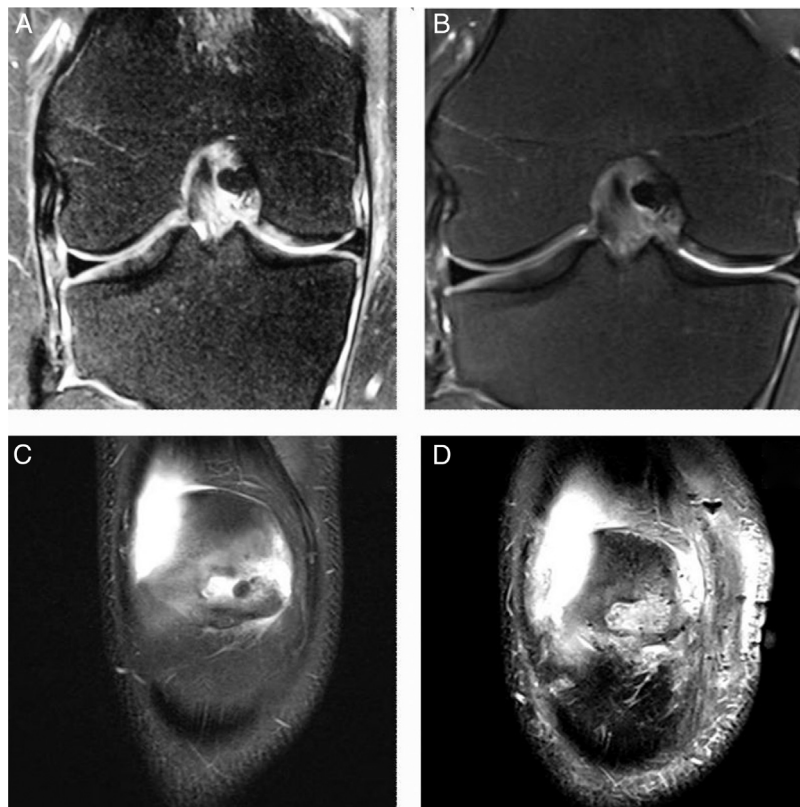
Magnetic resonance imaging of two patients who underwent surgical treatment, preoperatively and 1 year postoperatively. (A) A T2-weighted coronal section showing a chondral lesion on the inner side of the medial femoral condyle. (B) A postoperative image showing the resurfacing of the previous cartilaginous lesion. (C) A coronal image of the patella, showing the lesion area on the medial facet. (D) Area resurfaced by the collagen membrane.
